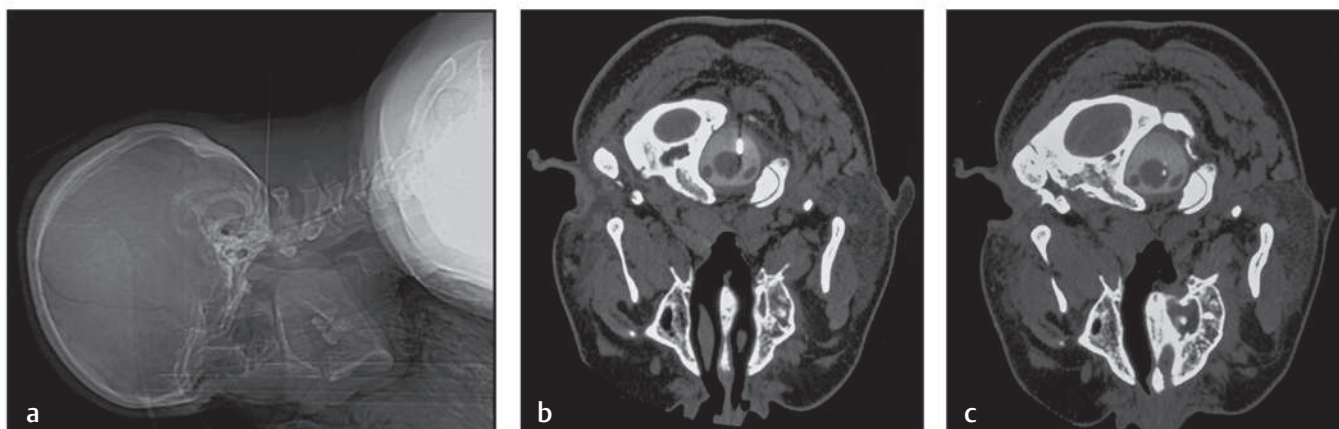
The CT-guided trigeminal tractotomy-nucleotomy (TR-NC) procedure. (a) Position of the needle at the occiput–C1 level in the lateral scanogram. (b) Final position of the needle in the axial CT scan. (c) Final position of the electrode.
